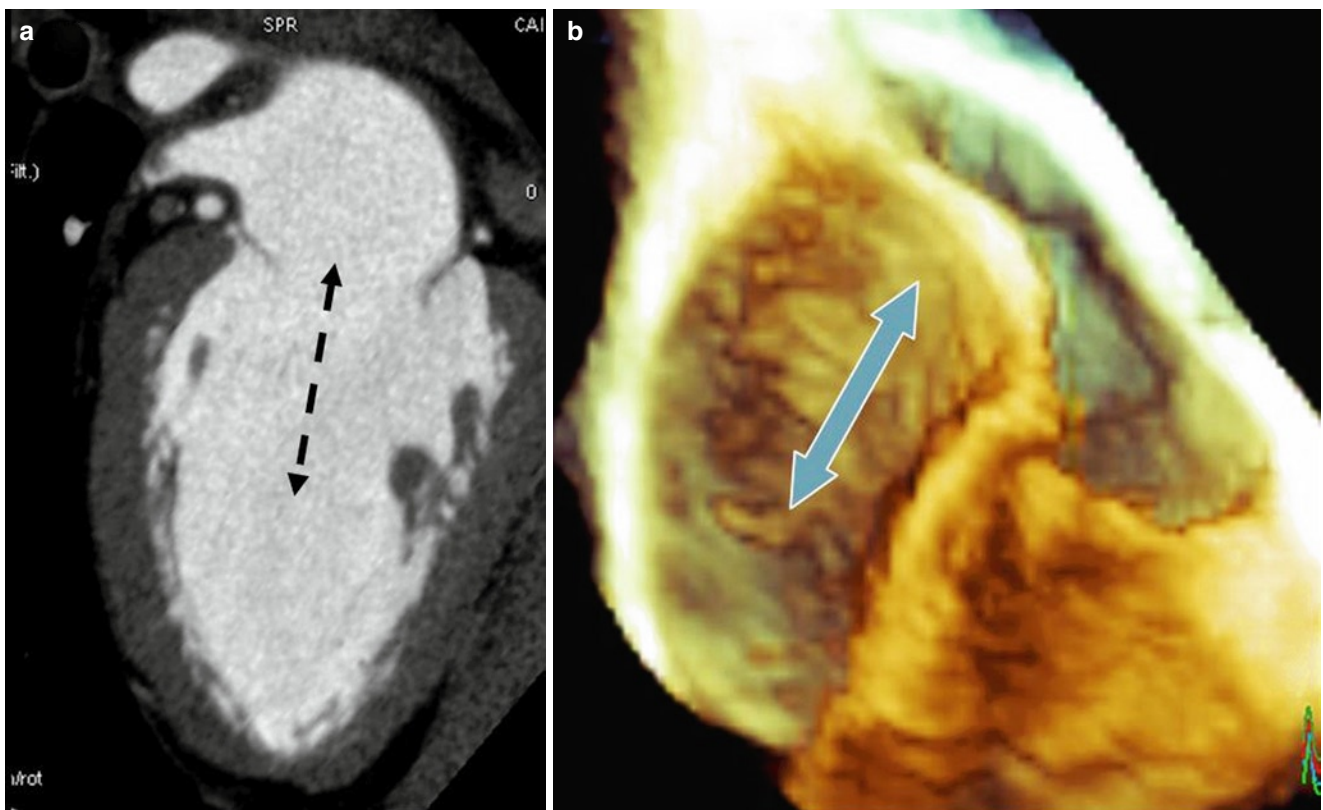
(a) CT slice image and (b) RT 3D TEE showing the extent of the inlet portion of the left ventricle (*double-headed arrows*)
